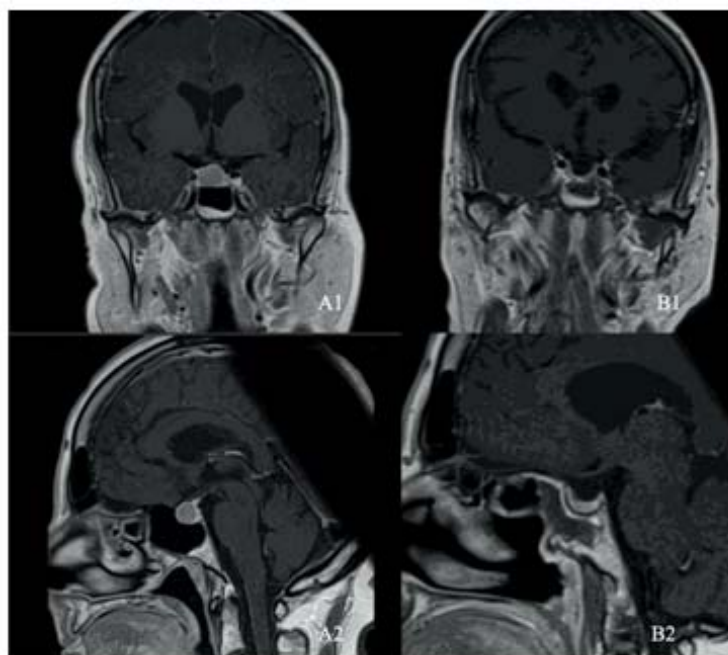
Pre-postoperative MRI A1: preoperative T1 coronal MRI A2: preoperative T1 sagittal MRI B1: postoperative T1 coronal MRI B2: postoperative T1 sagittal MRI
